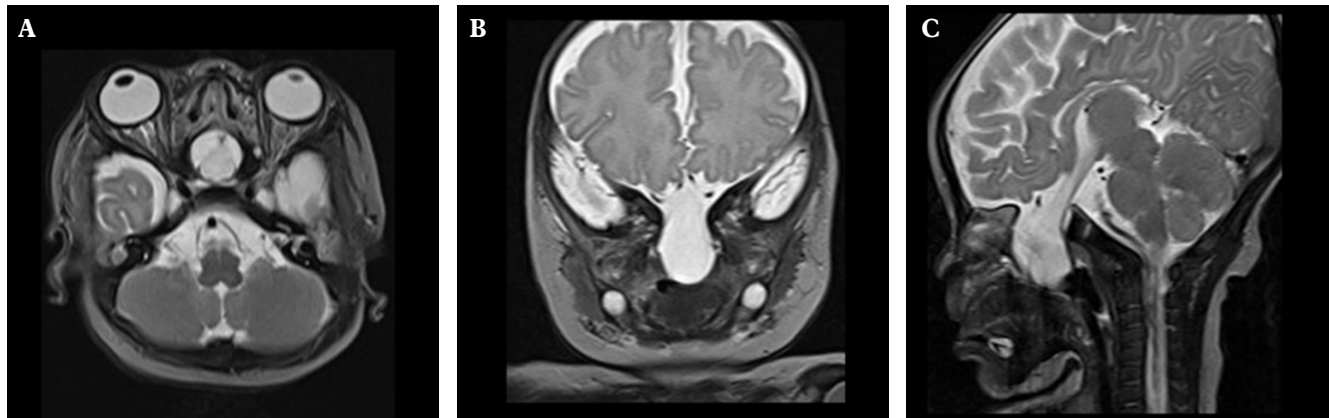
T2 Weighted MRI BRAIN: (A) axial cut showing hyperintense mass anterior to optic chiasm; (B) coronal cut showing hyperintense mass extending inferiorly into the nasal cavity; (C) sagittal cut showing homogenous hyperintensity extending up to the sellar floor.
